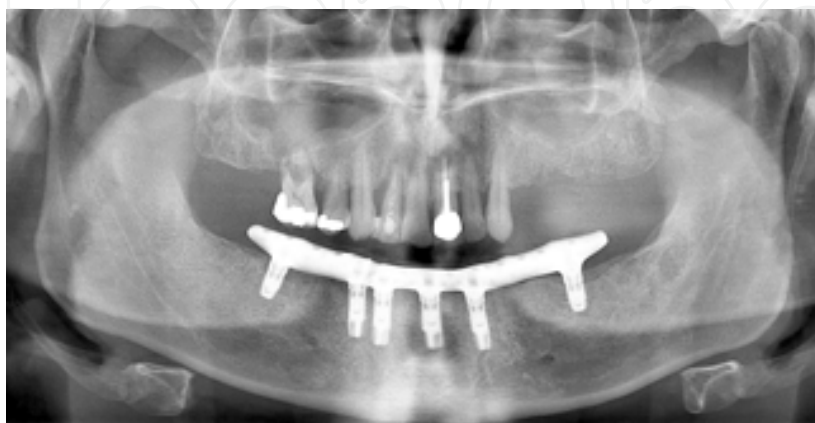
Panoramic radiograph at delivery.
